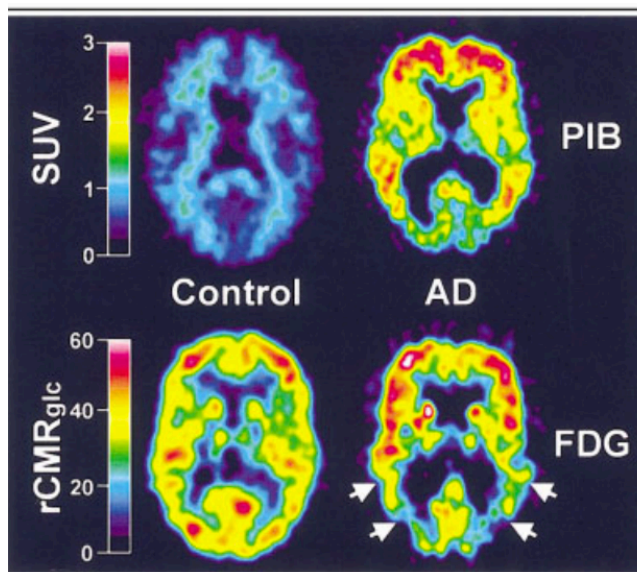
Amyloid deposition as seen by PiB and glucose uptake, as represented by FDG in Alzheimer disease and healthy controls. Reprinted by permission from John Wiley and Sons: *Annals of Neurology*¹⁴, copyright 2004.
